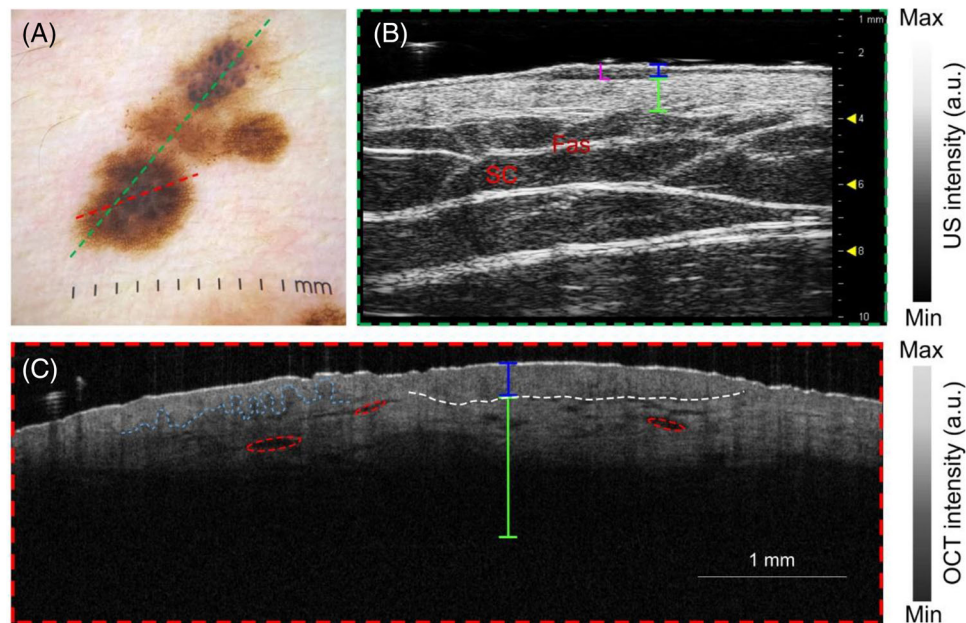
Compound nevus (CN) of phacomatosis pigmentokeratotic (PPK) on the left cheek. (A) Dermoscopy image of CN-cheek with central hyperpigmentation, large peripheral globules, and peripheral blue-white veil. Red dashed line—optical coherence tomography (OCT) probe field (6 mm). Green dashed line—high-frequency ultrasound (HFUS) probe field 16 mm. (B) HFUS image of the CN demonstrates a hypoechoic “straw hat sign” typical for CN. Areas of noise must be noted. L—lesion. Blue line—epidermal entry echo. Green line—dermis. Yellow dashed circle—focal areas of increased collagen surrounding CN. (C) OCT image of the CN-cheek. Blue line—epidermis. Green line—dermis. Pink dashed line—areas of fused and broadened rete ridges in the epidermis. Blue arrows—elongated rete ridges extending into papillary dermis.
